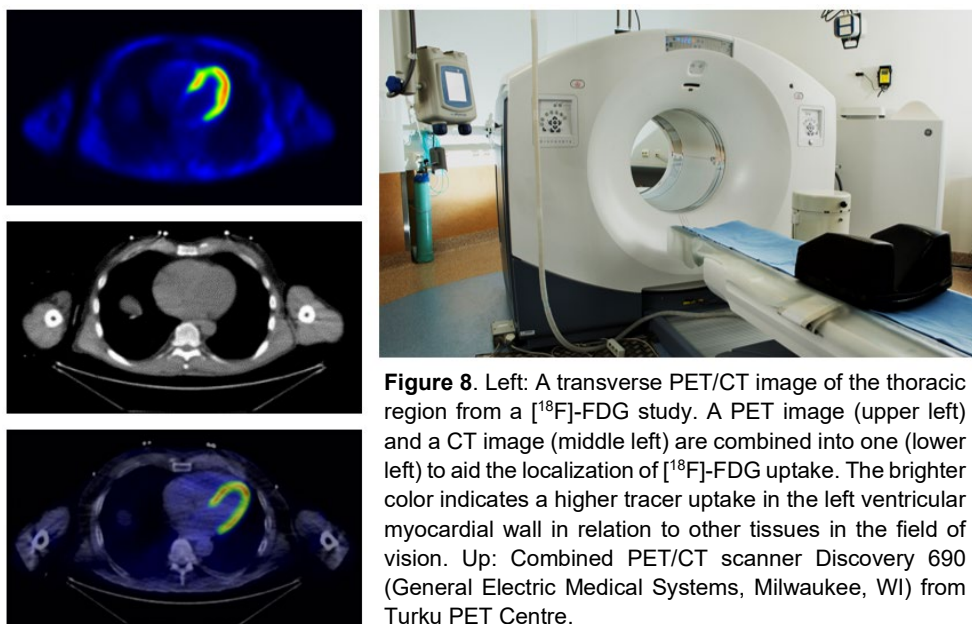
Left: A transverse PET/CT image of the thoracic region from a [¹⁸F]-FDG study. A PET image (upper left) and a CT image (middle left) are combined into one (lower left) to aid the localization of [¹⁸F]-FDG uptake. The brighter color indicates a higher tracer uptake in the left ventricular myocardial wall in relation to other tissues in the field of vision. Up: Combined PET/CT scanner Discovery 690 (General Electric Medical Systems, Milwaukee, WI) from Turku PET Centre.
